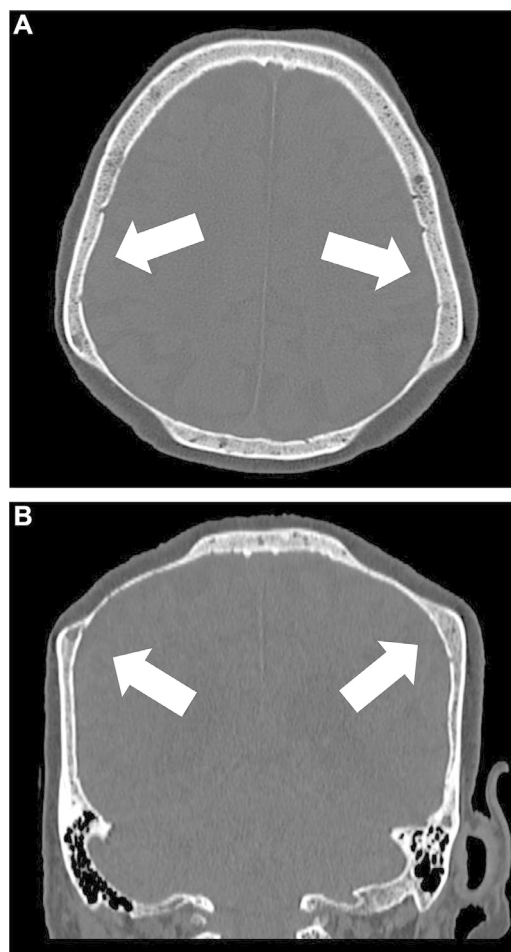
Axial (A) and coronal (B) CT head images in bone window, demonstrating symmetric thinning of both parietal bones (white arrows). The affected areas appear as bilateral concave depressions with loss of the outer table and diploic space, while the inner table remains intact. The contour of the skull vault is smoothly indented at these sites, and no fracture lines are seen.
